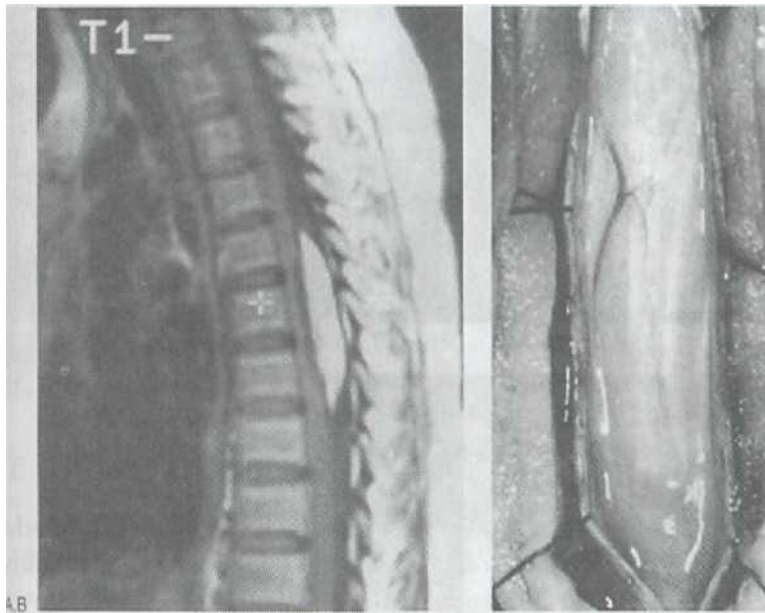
Lipoma. (A) T1 sagittal magnetic resonance image of the thoracic spine without intravenous contrast shows a hyperintense intradural lesion posterior to the spinal cord at T5-7. The cord is compressed. (B) Intraoperative photograph confirms the subpial location of the lipoma.
